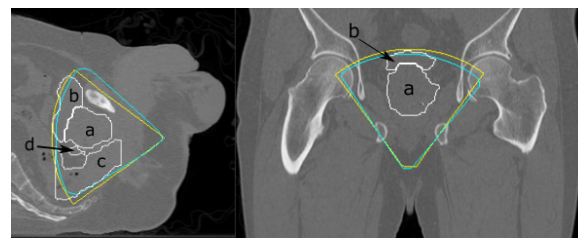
Center slices of the patients' CT volume in both sagittal and coronal direction. The US sector proposed by the algorithm is superimposed in yellow, while the sector actually used by the physician is displayed in cyan. In addition, the anatomical structure delineations are displayed in white: (a) prostate, (b) bladder (c) rectum and (d) seminal vesicles.
